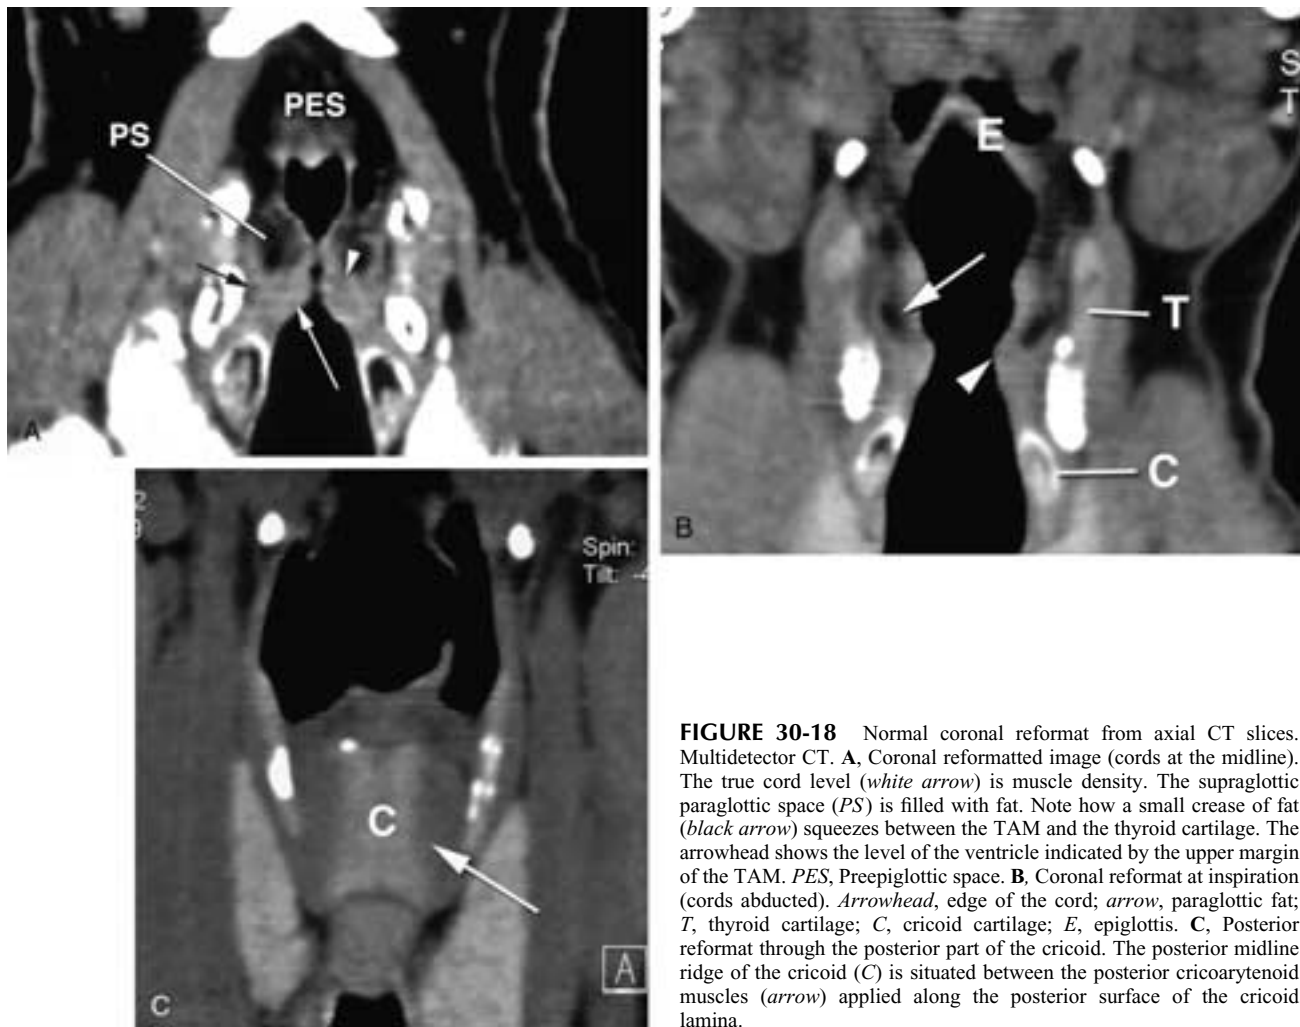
Normal coronal reformat from axial CT slices. Multidetector CT. A, Coronal reformatted image (cords at the midline). The true cord level (*white arrow*) is muscle density. The supraglottic paraglottic space (*PS*) is filled with fat. Note how a small crease of fat (*black arrow*) squeezes between the TAM and the thyroid cartilage. The arrowhead shows the level of the ventricle indicated by the upper margin of the TAM. *PES*, Preepiglottic space. B, Coronal reformat at inspiration (cords abducted). *Arrowhead*, edge of the cord; *arrow*, paraglottic fat; *T*, thyroid cartilage; *C*, cricoid cartilage; *E*, epiglottis. C, Posterior reformat through the posterior part of the cricoid. The posterior midline ridge of the cricoid (*C*) is situated between the posterior cricoarytenoid muscles (*arrow*) applied along the posterior surface of the cricoid lamina.
